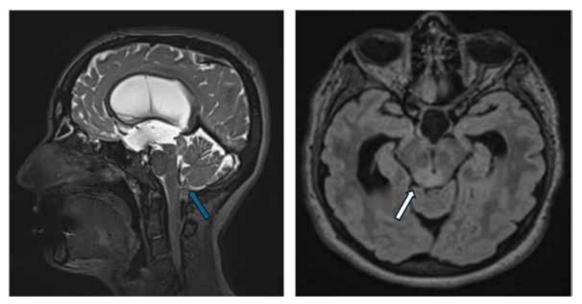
Sagittal T2WI scan shows marked enlargement of the lateral and third ventricles, resulting from obstructive hydrocephalus caused by a tectal tumor. Chiari malformation is not demonstrated (blue arrow). Axial FLAIR scan at the midbrain level, shows a well-defined hyperintense tectal plate glioma (white arrow).
